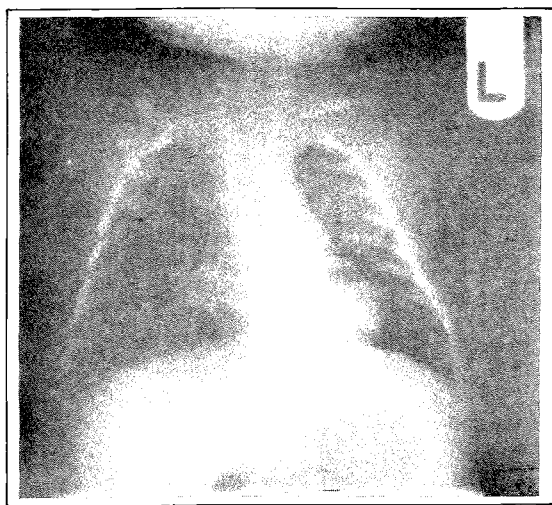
Chest radiograph after one month showing various sizes pneumatoceles in the right mid and lower zones.
